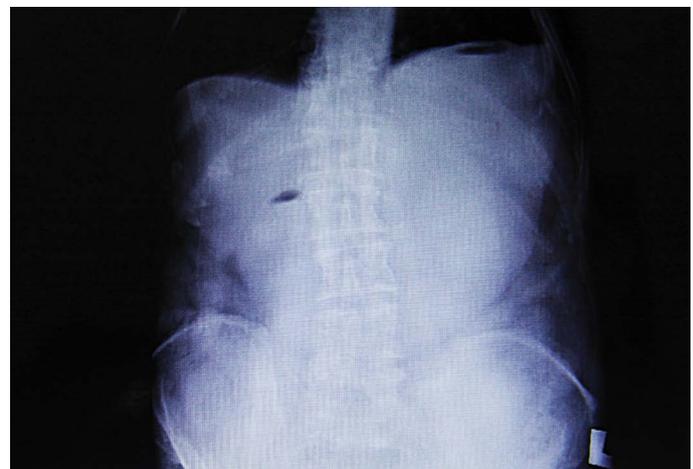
Abdominal radiograph, taken with the patient standing, showing the stomach filled with fluid content.
